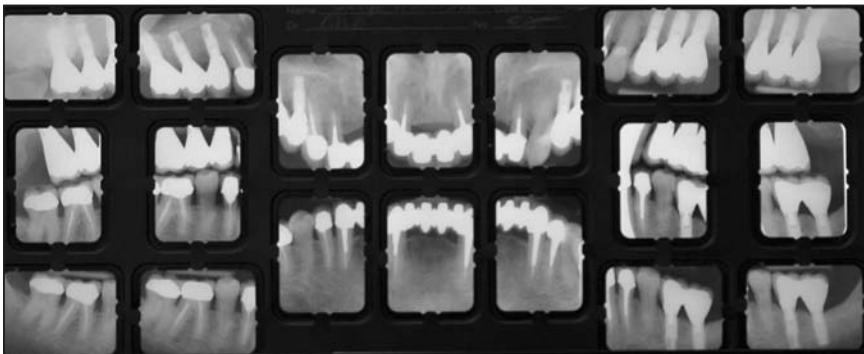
Periapical radiographs of completed treatment. Nos. 12 and 17 were extracted, some post and cores were replaced and implants were placed the edentulous areas.
